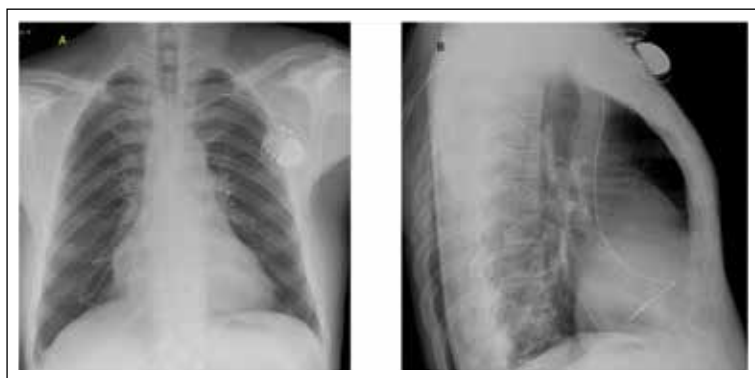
Another case of right ventricular endomyocardial fibrosis (RVEMF) who underwent endocardial VVI pacemaker insertion. RV basal septal / inflow septal pacing was done as the body and apex of the right ventricle were obliterated. Frontal (A) and lateral chest radiographs(B) showing the lead positions.
